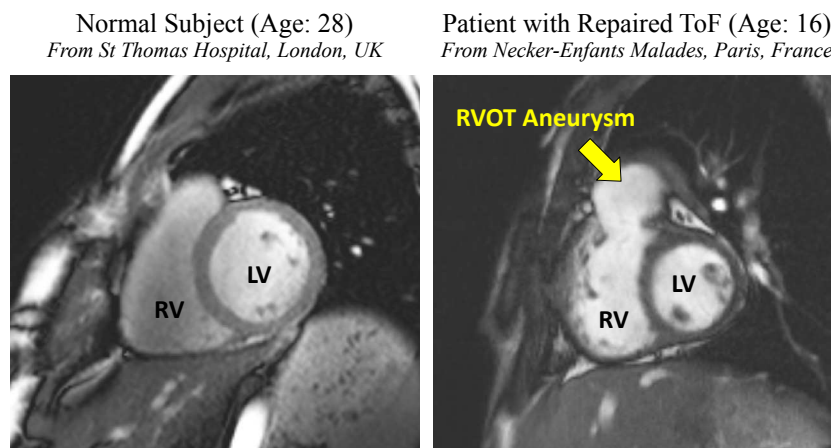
Left panel:* MRI of a normal heart. *Right panel:* MRI of a patient with repaired tetralogy of Fallot. Observe the dilated right ventricle (RV) compared to the left ventricle (LV) in ToF in contrast with the normal heart. The patient also has an RVOT aneurysm due to the corrective patch.
